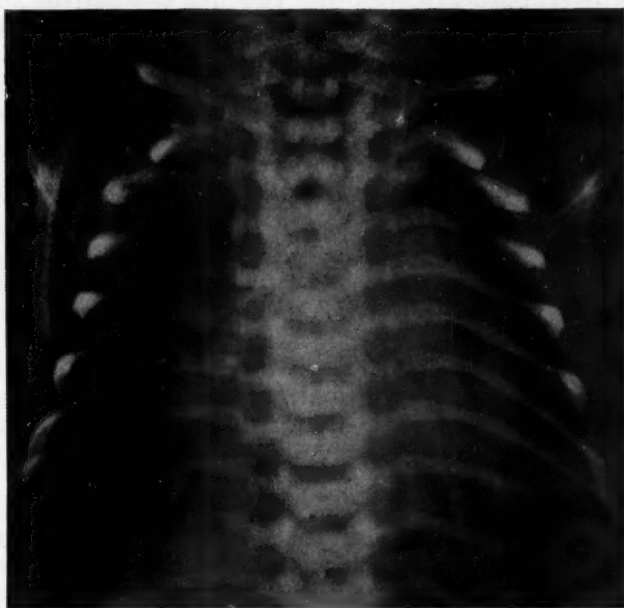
Chest x-ray at age 2 days. The cardiac shadow is large. The indentations in each lung apex are thought to be the lower poles of the thyroid gland.
